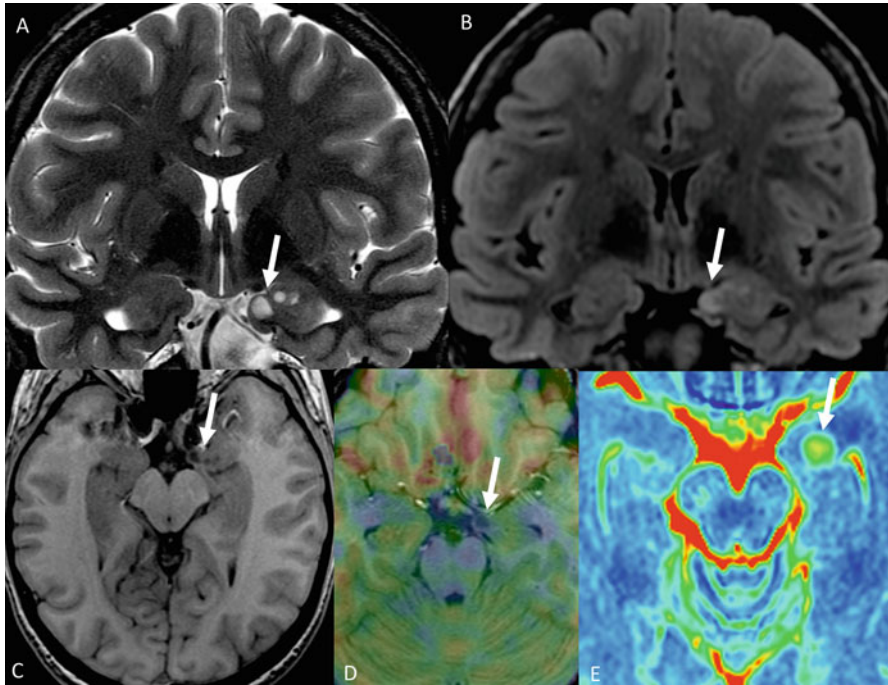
Advanced imaging in a case of pseudocystic type 1 DNET of the left cerebral amygdala (arrow) on coronal T2 (a) and FLAIR (b) slices, axial T1 (c), ASL with co-registration of cerebral blood flow map on a T1 slice (d) showing a decrease of the local cerebral blood flow of the DNET in comparison to the right amygdala. Finally, the apparent diffusion coefficient map (e) shows an increased ADC of the DNET in comparison to adjacent cortex
